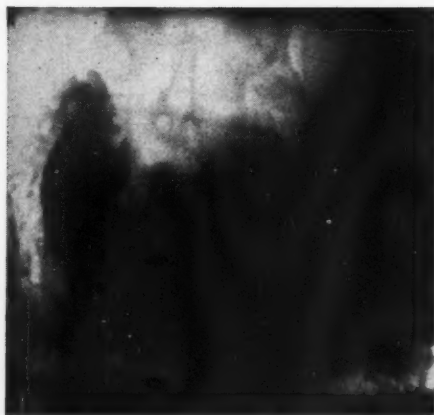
Case 1. A roentgenogram, taken two years before the present admission, showing a prepyloric defect which was constant in all films. At this time a diagnosis of prepyloric ulcer was made. Gastric analysis showed a total acidity of 61 per cent and free hydrochloric acid of 50 per cent. No blood was present.
